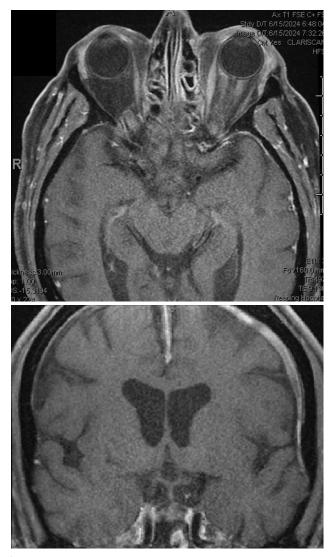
A magnetic resonance imaging (MRI) scan of the brain and orbit showed inflammation surrounding the left optic nerve, as well as pachymeningitis along the left cerebral convexity and in the interhemispheric fissure, indicating the presence of hypertrophic pachymeningitis.
